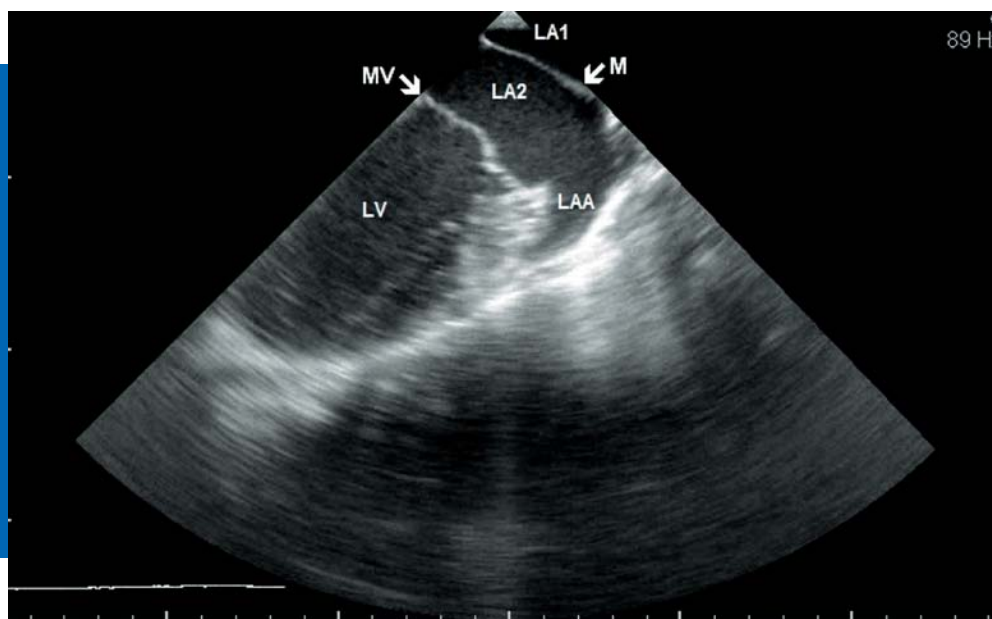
Transthoracic echocardiography showing left atrial membrane.
